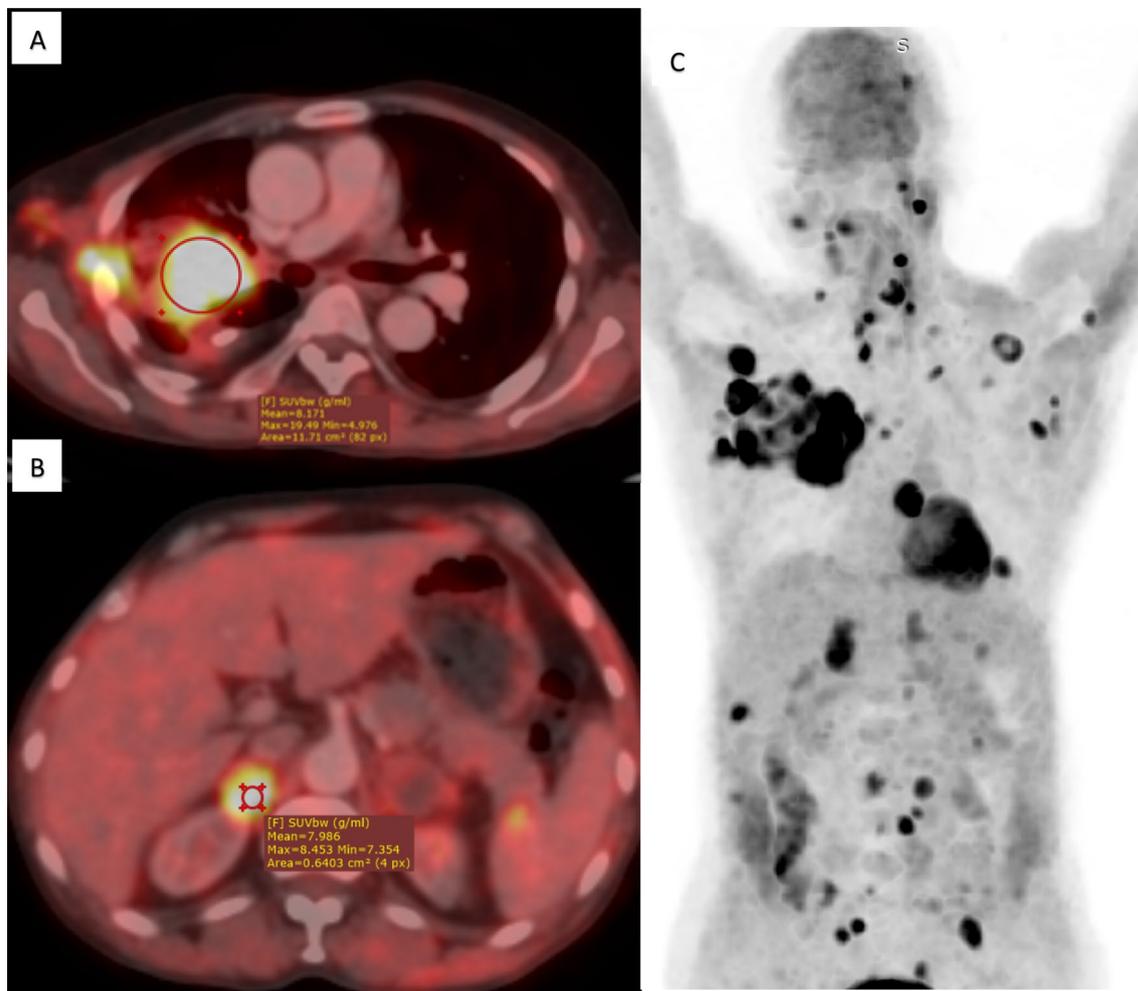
A 55-year-old male patient whose CT chest revealed multiple pulmonary masses, underwent (FDG) PET/CT scan. (Fig. 1). A–C (FDG) PET/CT, A Axial view: A large infiltrative metabolically active right lung upper lobe soft tissue mass lesion measures $7.4 \times 12 \times 8.5$ with max.SUV ~ 19.15 . B Right adrenal lesion measuring 2.5 cm, with max.SUV ~ 8.4 . C Full-body coronal MIP PET showing the primary lung mass and metastasis to lymph nodes, cerebral, pleural, adrenal, osseous deposits. The tissue sampling was obtained via endoscopic biopsy proved to be squamous cell carcinoma (SCC)
